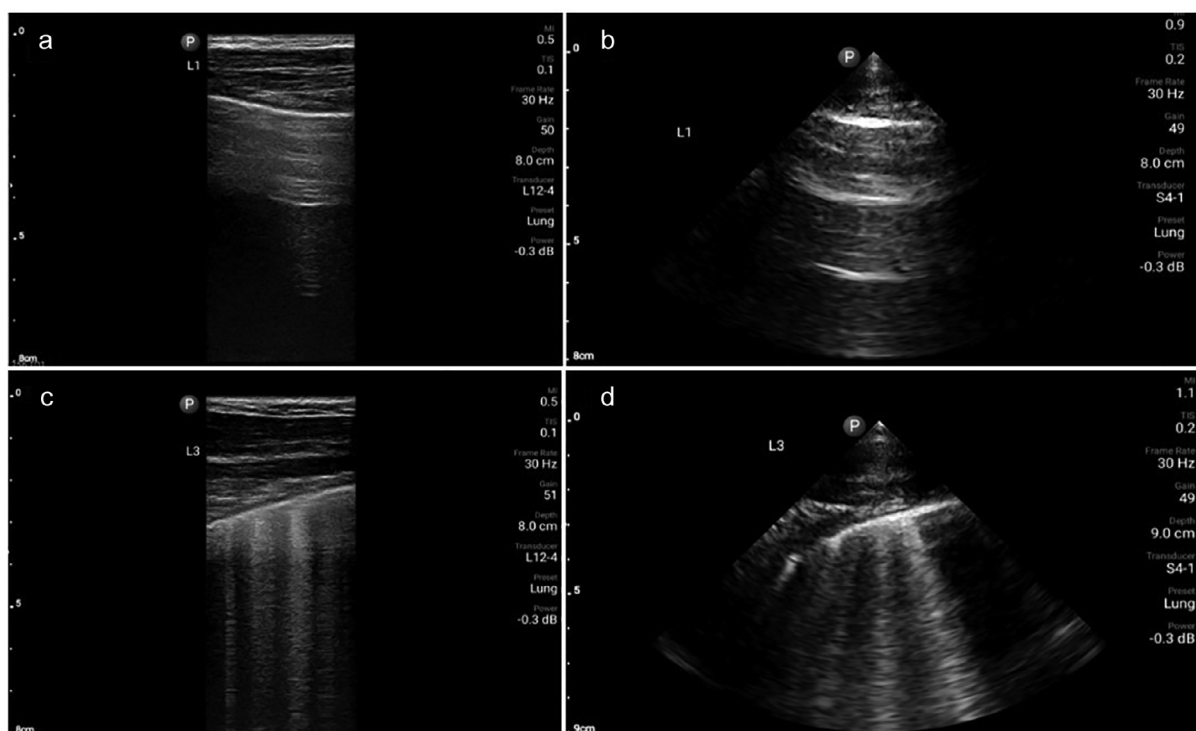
LUS images acquired with the linear and the sector array probe in the same lung region. The upper LUS images show horizontal A-lines, indicating normally aerated lung tissue, scanned with the linear probe (a) and the sector array probe (b). The lower LUS images show vertical B-lines, indicating diminished aeration of lung tissue, scanned with the linear probe (c) and the sector array probe (d). LUS = lung ultrasound.
